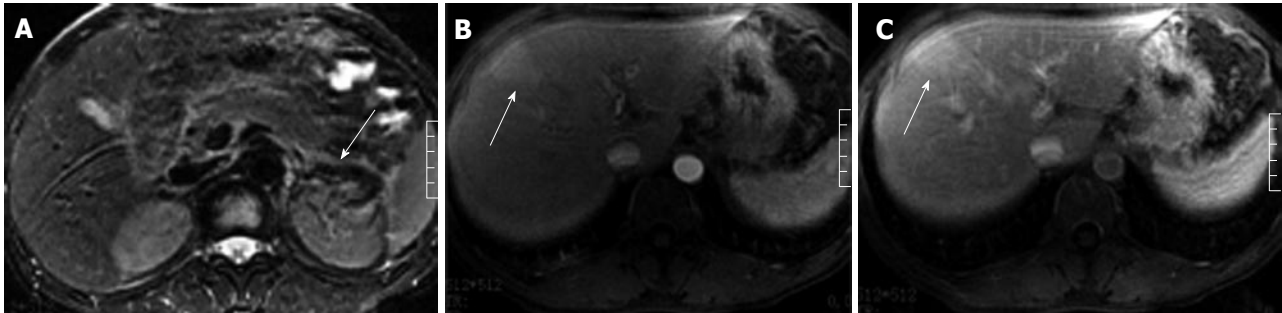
A 45-year-old man with acute pancreatitis without gallbladder or common bile duct abnormalities. Fast recovery fast spin-echo T2-weighted image (A) shows the left anterior pararenal space fluid collection (arrow). Wedge-shaped hepatic abnormal perfusion (arrow) is found in the left inner lobe of the liver on the arterial phase (B) and venous phase images (C).
